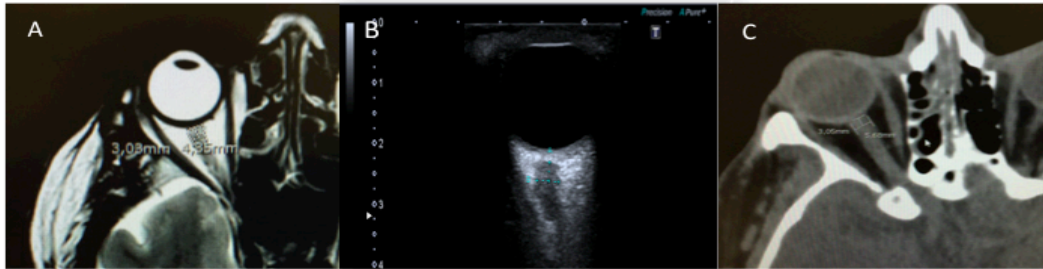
Measurement of ONSD. A: Methodology to measure ONSD on Magnetic Resonance. The axial proton density/T2-weighted turbo spin-echo fat-suppressed sequence is used to measure ONSD and optic nerve diameter B: Ultrasonographic picture of the optic nerve system. Caliper identifies the site of ONSD measurement 3 mm behind the retina. C: Computed Tomography image of the optic nerve sheath. Using electronic calipers ONSD is measured 3 mm behind and in a perpendicular vector with reference to the orbit.
